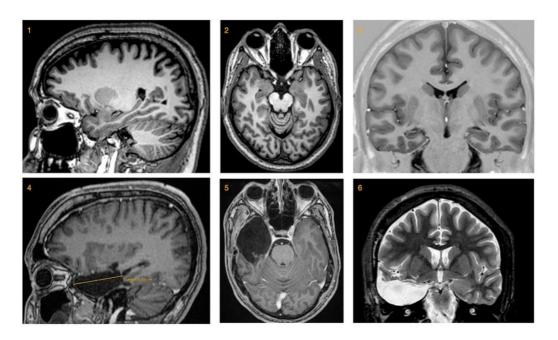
MRI (coronal, axial and sagittal) pre and postoperative of surgery with anterior temporal lobectomy for right hippocampal sclerosis.
